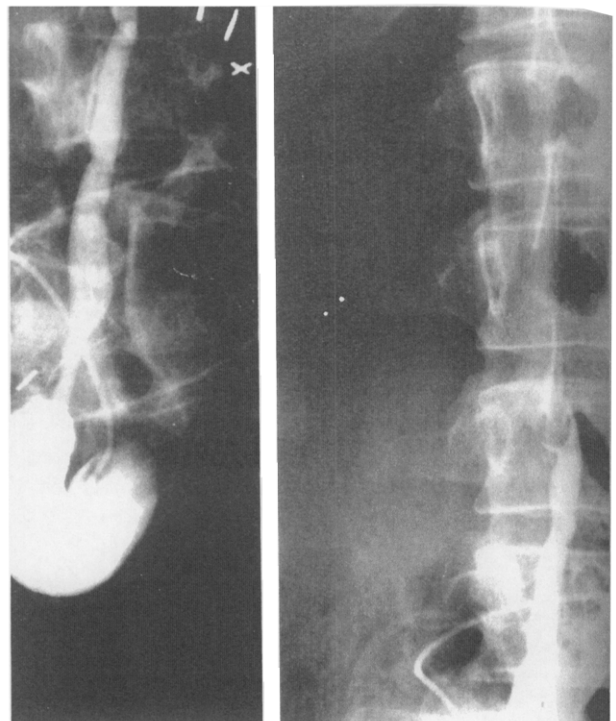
Case 1. Ileal loopogram. On right radiograph note obstruction of proximal ureter by filling defect (consistent with calculus).
